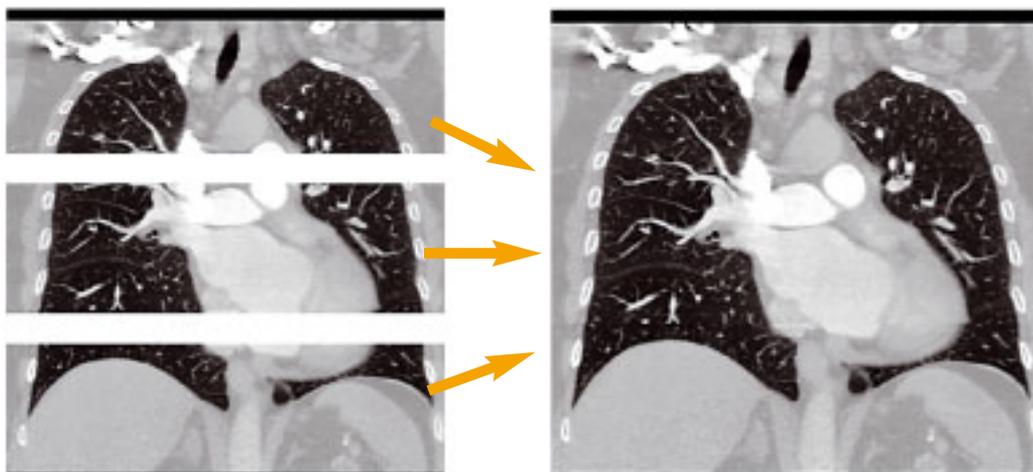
Example of a thoracic CT study in stitching mode. The final image has been conjoined seamlessly from the three individual images.
